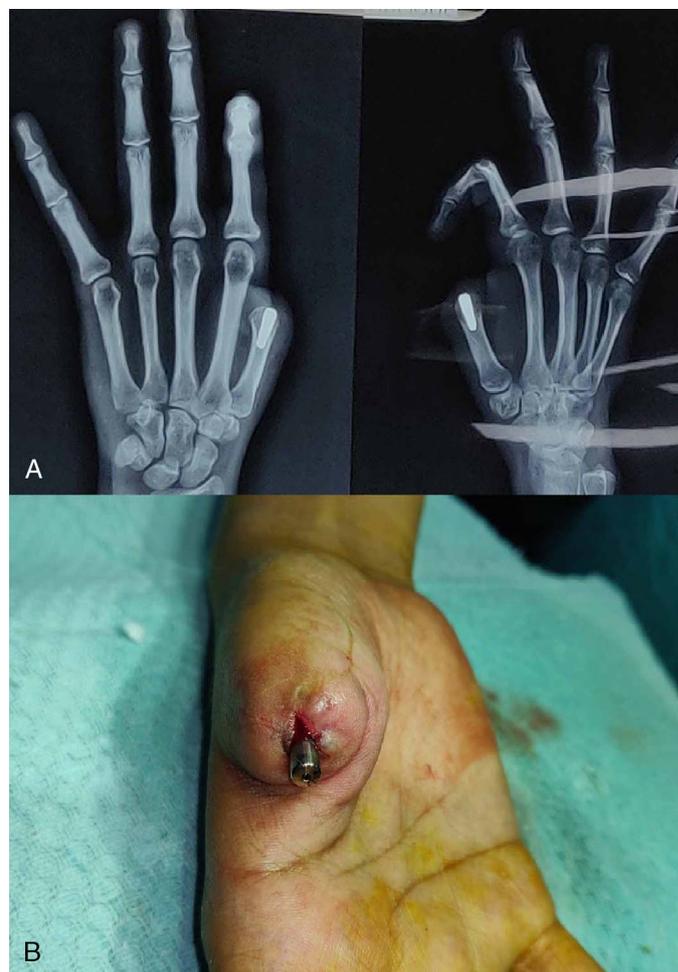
A, Radiograph at 4 months, lateral and palmar view. B, Second stage surgery, healing abutment placed.
